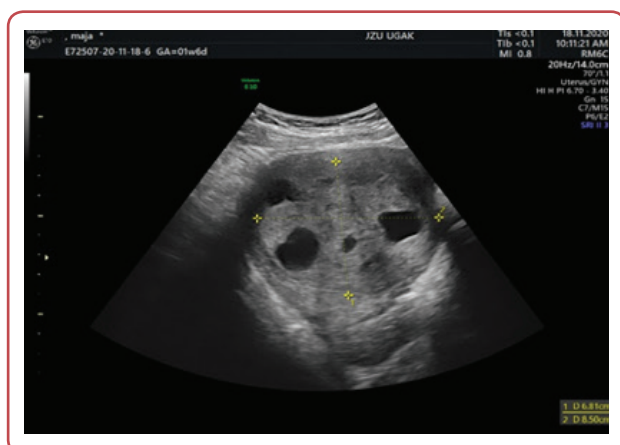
Transabdominal ultrasound - cross sectional imaging of leiomyoma with cystic changes
